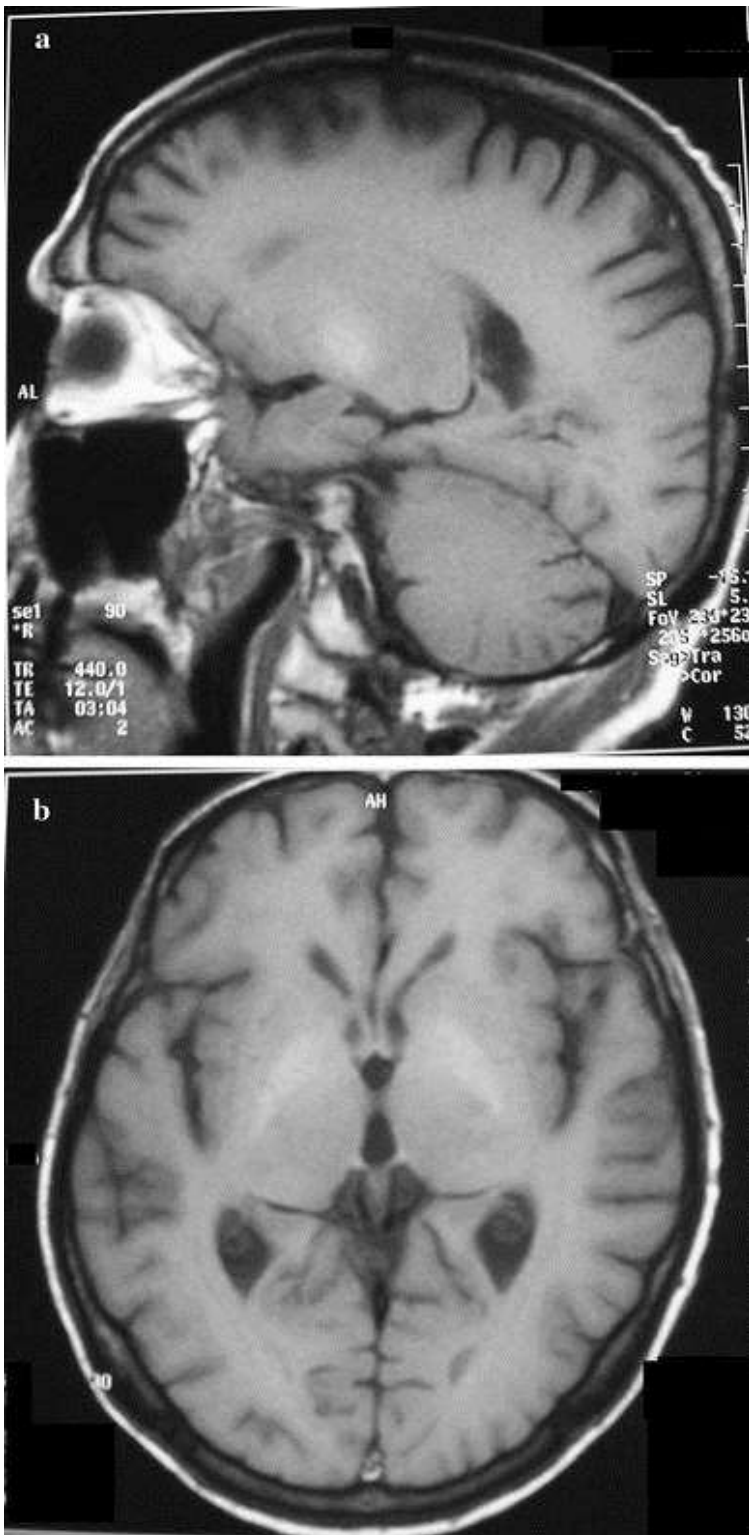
T1-weighted images of brain MRI showing bilateral pallidal hyperintensity in Patient 10; a sagittal image, b axial image.
